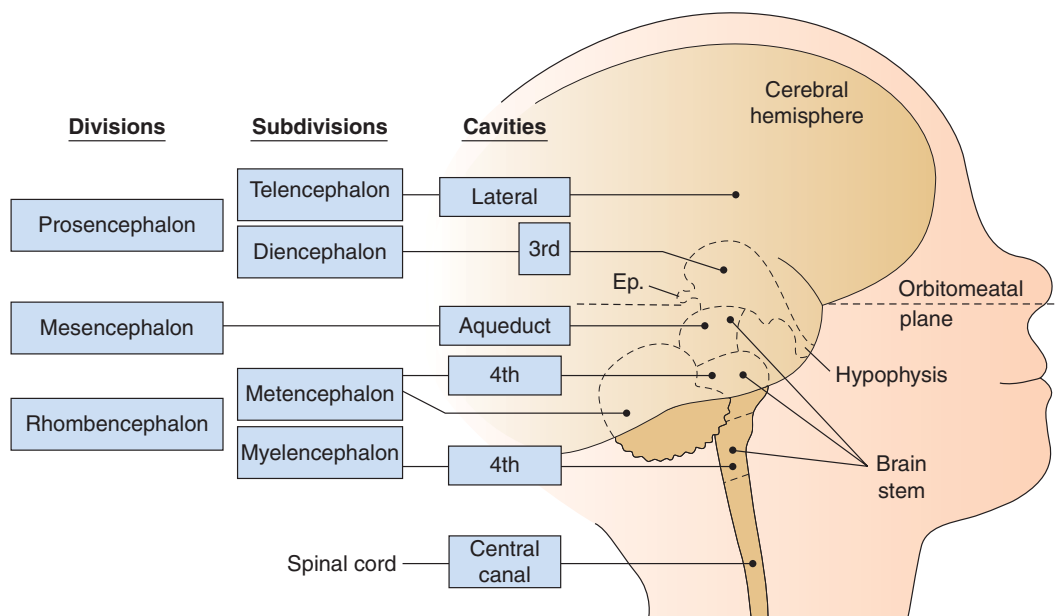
The divisions, subdivisions, and brain cavities seen in an infant's brain. The metencephalon consists of the cerebellum and the pons. The myelencephalon is the medulla oblongata. The brain stem comprises the midbrain, pons, and medulla. The third ventricle is mainly diencephalic, but it is partly telencephalic. The central canal is mainly in the spinal cord, but it is partly in the medulla. All of these parts are present by 5 postfertilizational (7 postmenstrual) weeks. The subdivisions and the cavities can be detected by high-frequency transvaginal sonography, but only from about 8 to 8½ postmenstrual weeks. (From O'Rahilly and Müller, 2001,³⁷ with permission.)
